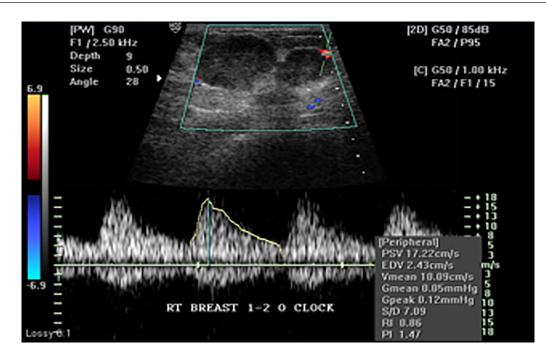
(Patient no. 1): Color Doppler in right breast, at 1-2 o'clock location shows peripheral vascularity, the pattern is of arterial flow. The RI is 0.8 and PI is 1.47, a feature suggesting malignancy.
